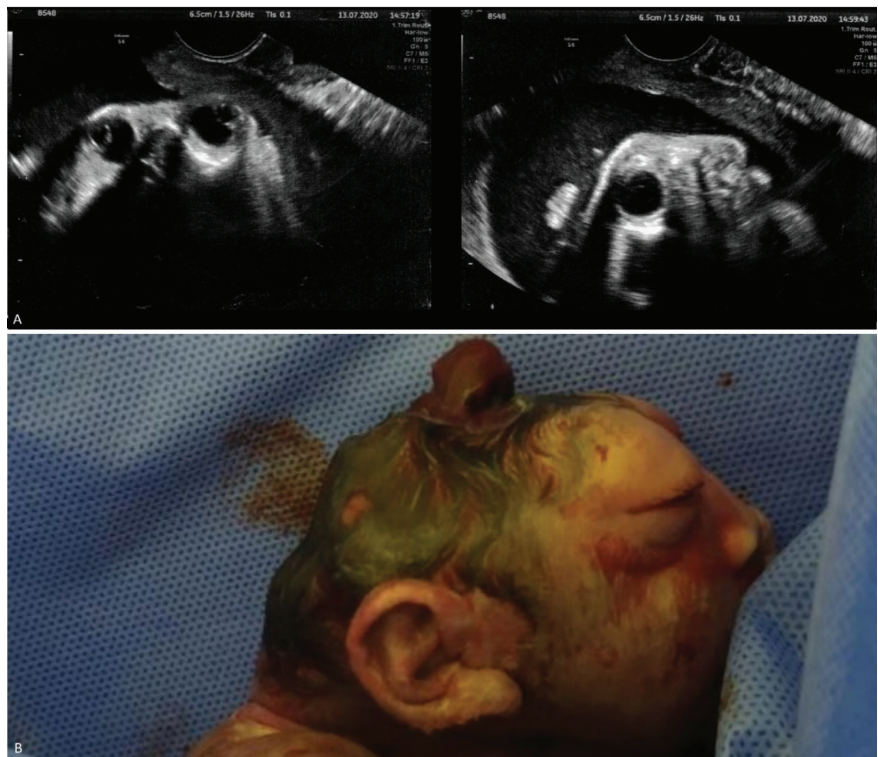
Ultrasound findings: Frog eye sign and absence of structures superior to orbits indicating anencephaly. B. Macroscopic features of anencephaly characterized by absence of cranial vault, low set ears and protruded eye balls.
